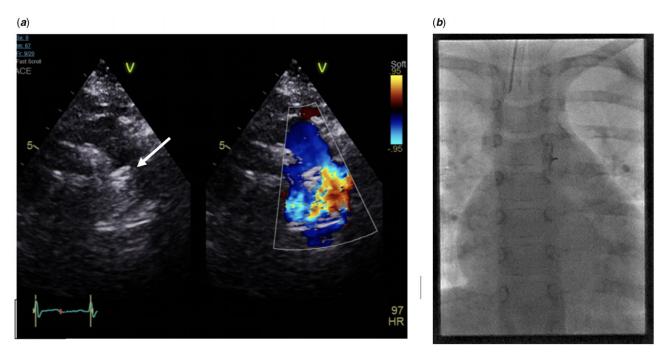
Device (arrow) seen distal to left subclavian artery with aliasing of flow on colour doppler (a) and fluoroscopy (b).
